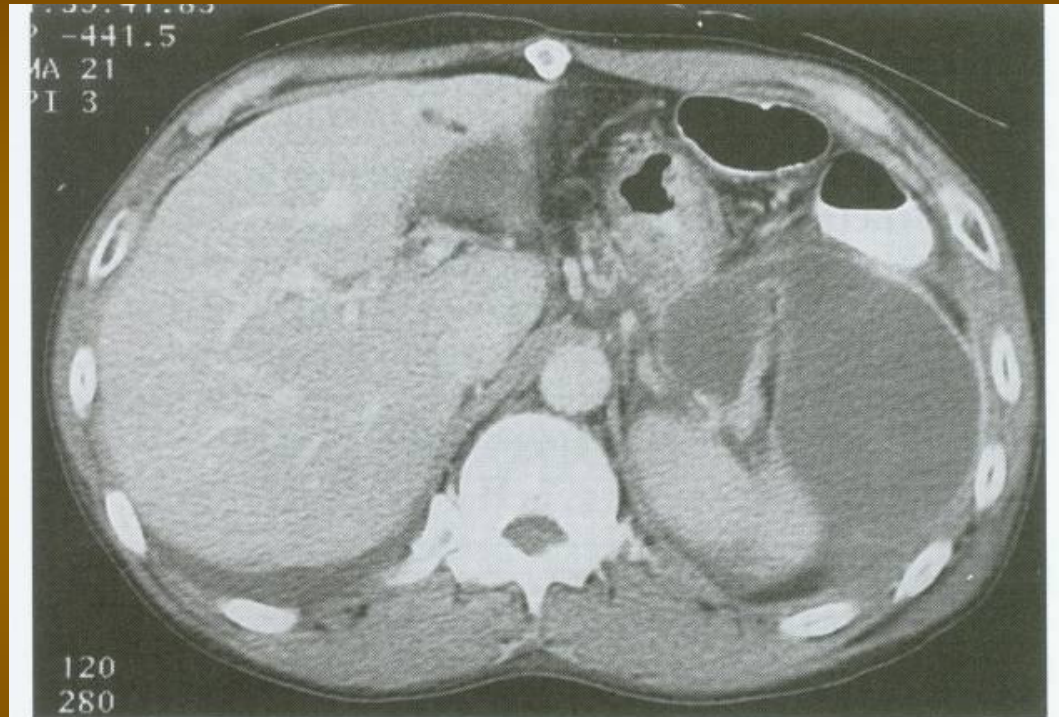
A computed tomography scan of a patient with an acute fluid collection 10 days after an episode of acute alcoholic pancreatitis. The collection is located anterior to the spleen and appears to have a thin wall. The acute fluid collection was not causing symptoms and gradually resolved with observation.
